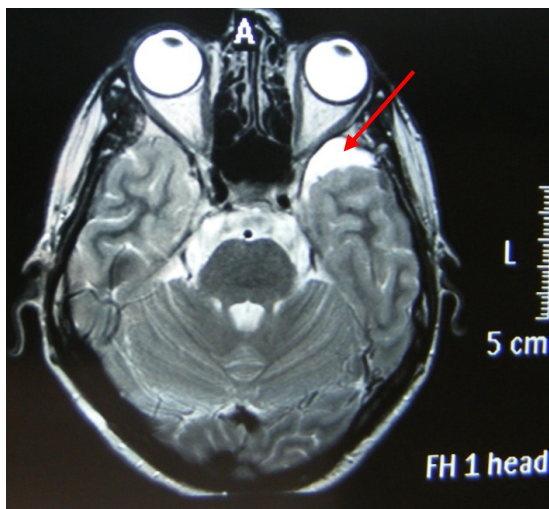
MRI-aspect of Gallasi I left temporal arachnoid cyst
